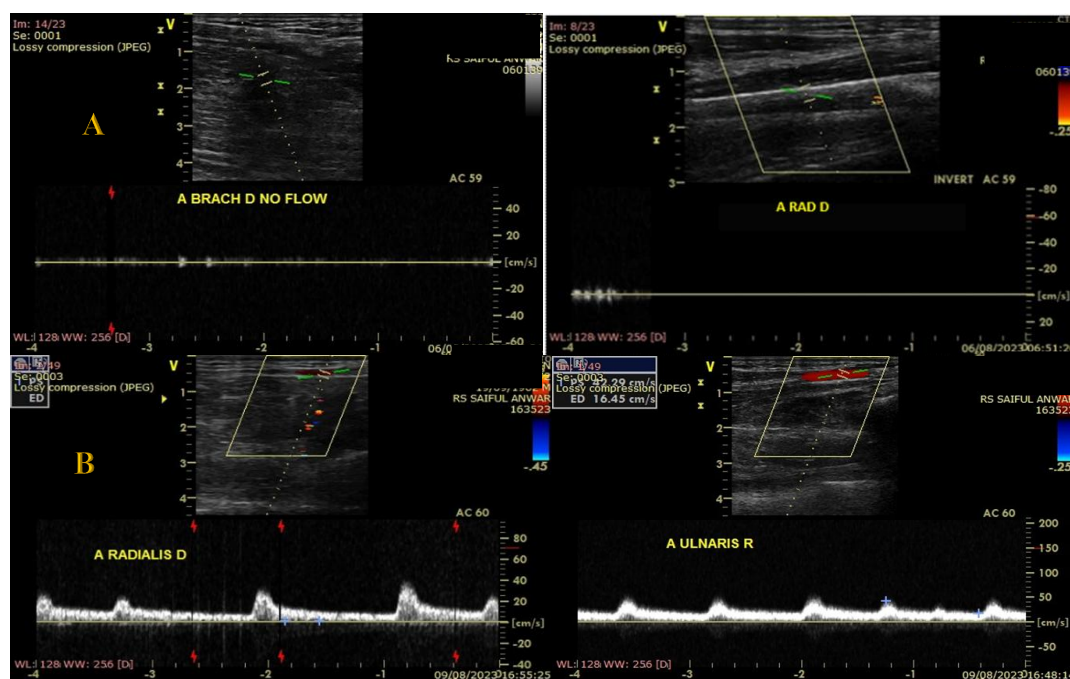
A. Duplex ultrasonography showed no flow at level right brachial artery and right radial artery B. Duplex ultrasonography evaluation showed monophasic flow at level right radial artery and right ulnar artery.
